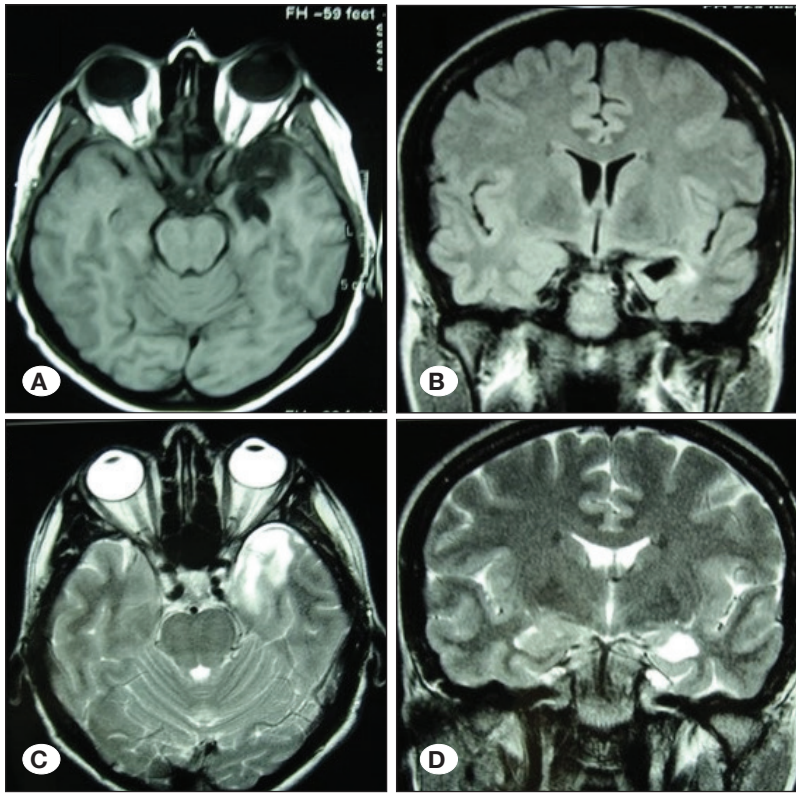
T1 (A: axial, B: coronal) and T2 (C: axial, D: coronal)-weighted brain magnetic resonance imaging of patient #1 show remnant tissues in the anteromesial regions of the left temporal lobe after the first surgery.
